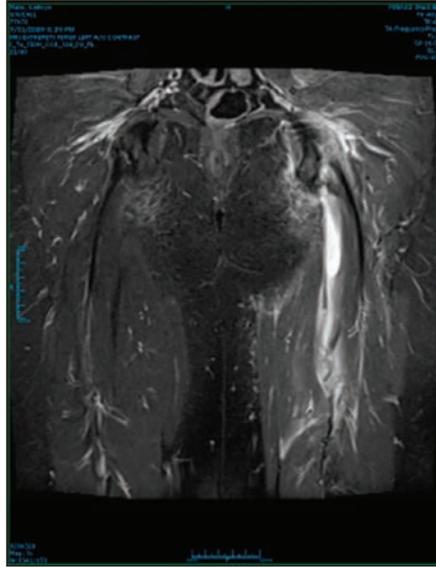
Pre-procedure MRI — demonstration of subject proximal hamstring tissue avulsion and hemorrhagic and inflammatory changes in the sub-acute period.
